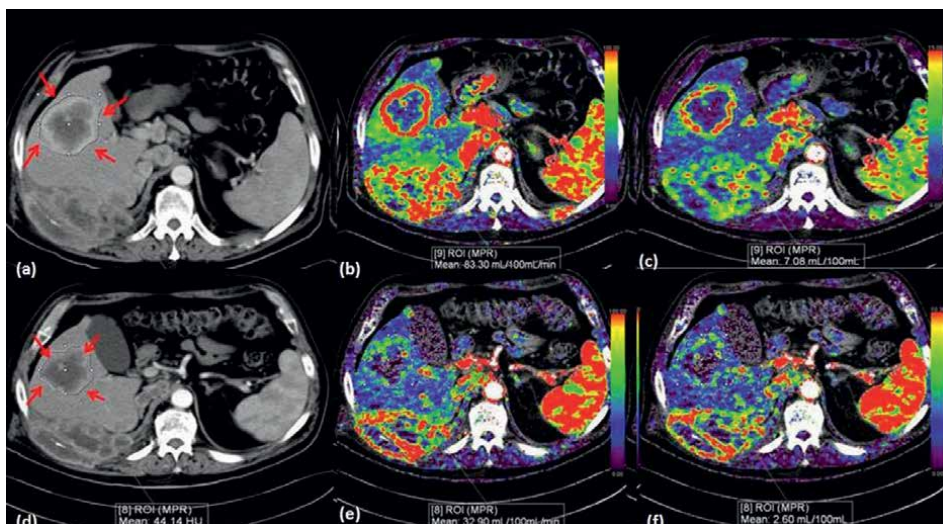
(a-c): Axial imaging of contrast enhanced and perfusion CT scan of metastatic lesion in right lobe of liver before starting treatment (red arrows). Primary lesion is RCC. Blood flow was $83.3 (\pm 70.48)$ ml/100 ml/min and blood volume is $7.08 (\pm 7.23)$ ml/100 ml. (d-f) Similar patient at 8 days of starting treatment. The blood flow reduced significantly to $32.90 (\pm 28.88)$ ml/100 ml/min and blood volume to $2.60 (\pm 3.35)$ ml/100 ml [17].
